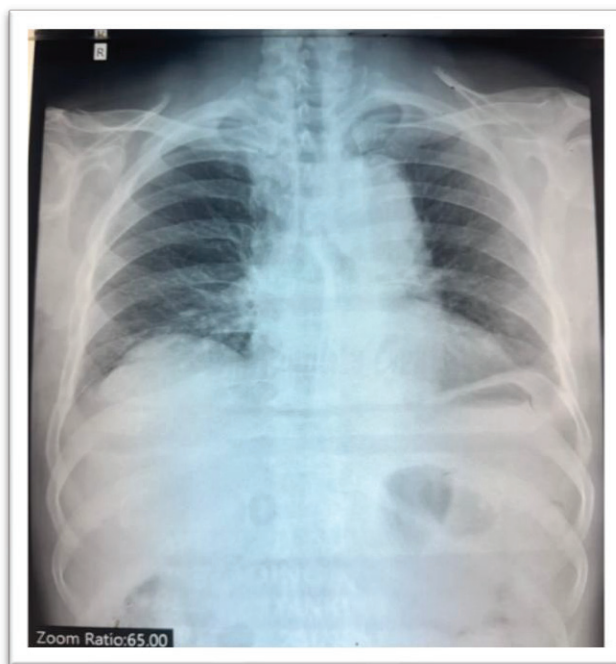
Chest X-Ray showing widening of the widen mediastinum.
